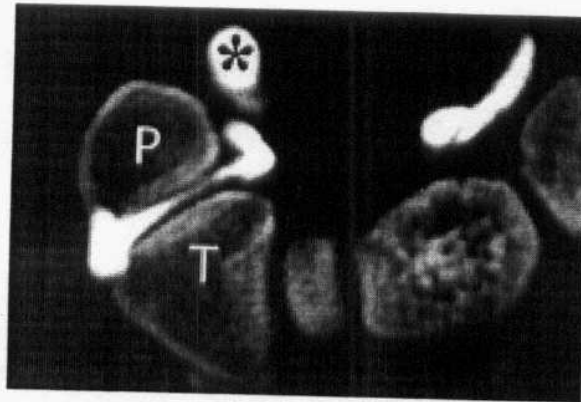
Guyon tunnel syndrome in a 54-year-old man with a pisotriquetrum ganglion, Axial CT arthrogram show a rounded ganglion (*), which displaces the ulnar artery (curved arrow) and compresses the ulnar nerve (straight arrow) against the pisiform (*P*). *T* = triquetrum (Quoted from Murphey, et al., 2004).
